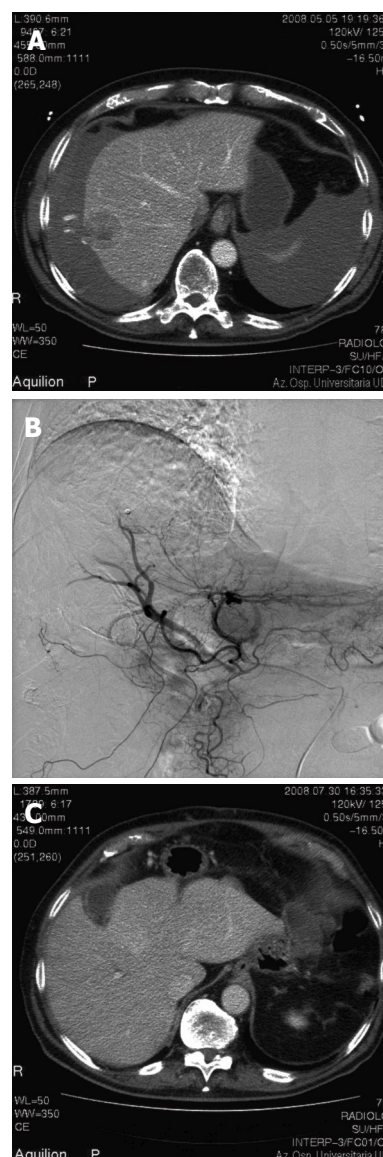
CT and TACE image of a 78-year-old male patients with hemoperitoneum from spontaneous rupture of undiagnosed HCC. A: Abdomen CT scan revealed a 3.5 cm focal lesion of the 6th hepatic segment actively bleeding, associated with hemoperitoneum; B: Trans-arterial chemoembolization (TACE) of the right hand side hepatic artery by means of selective catheterization; C: CT scan, performed two weeks after TACE, revealed an area of complete devascularization.
